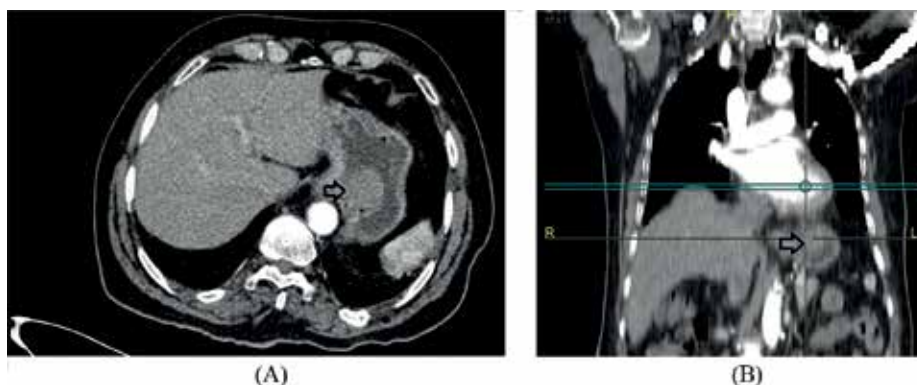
An axial (A) and coronal (B) CT image showing a well-defined mass lesion (arrow) in the anterior gastric wall in the proximal stomach measuring 2.9x2.5x2.7.
